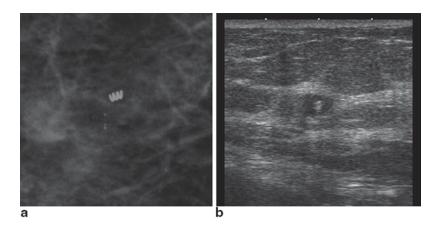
An ultrasound visible (water-soluble polyethylene glycol-based hydrogel) biopsy marker as seen on mammogram and ultrasound
